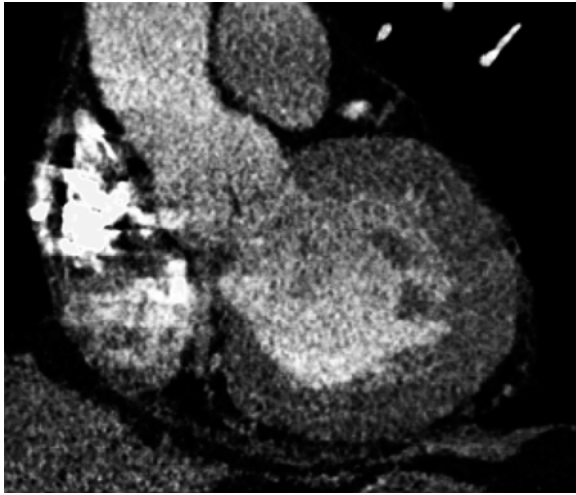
Coronary CT angiography examination in an obese patient (130 kg body weight). The examination was carried out using a 64-slice CT scanner with 0.6-mm collimation and 0.33-s rotation time. Images are reconstructed with 0.75-mm slice width and a medium-smooth reconstruction filter kernel. Visualization of the cardiac anatomy and the coronary artery tree is compromised due to too high image noise. (Case courtesy of Klinikum Grosshadern, University of Munich, Germany)
